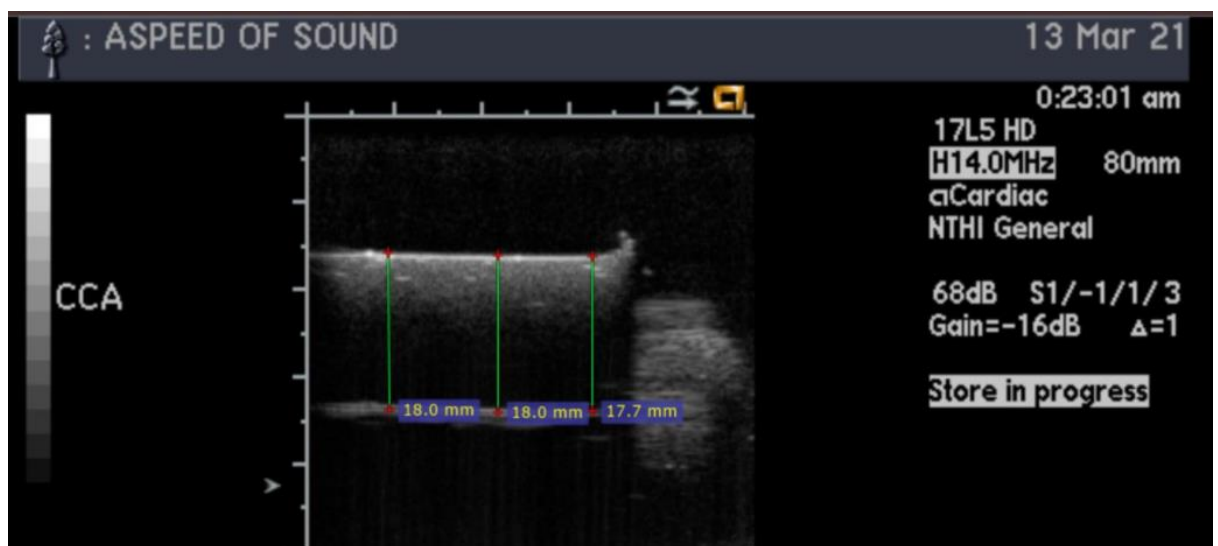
Speed of sound ultrasound experiment
